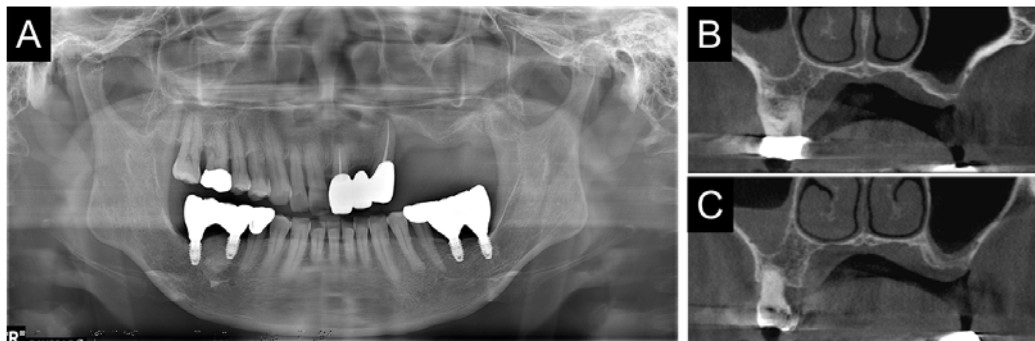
Radiographic examination before bone grafting for implant placement. (A) Panoramic radiograph after extraction of teeth (#24 and #27) and removal of implant (#25); (B, C) Reconstructed coronal view of cone-beam computed tomography at the posterior maxilla (#25-26 area).
